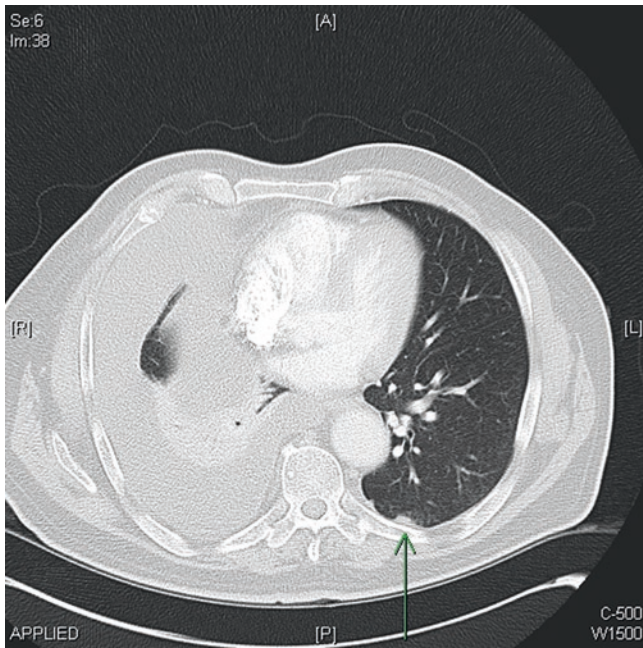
CT—early disease. Simple pleural effusion with contralateral asbestos plaque (*green arrow*)
